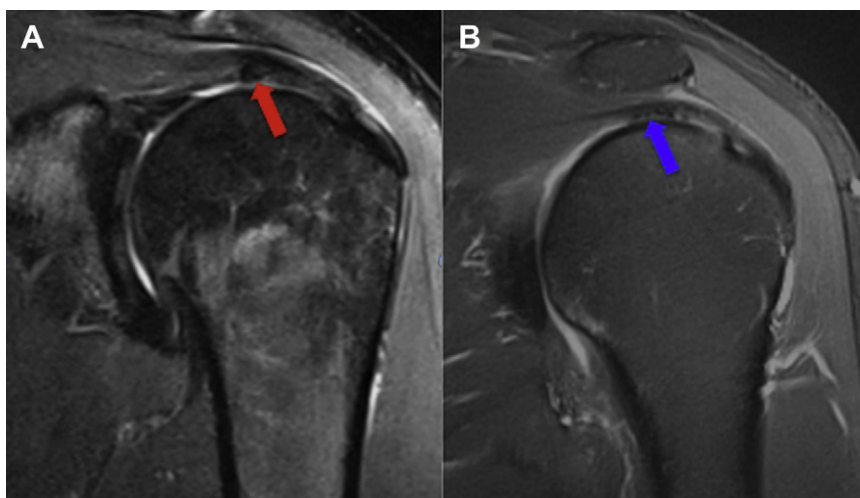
Variations in width and thickness of rotator cable. Coronal oblique fat-suppressed proton-density (A) and T2-weighted (B) images in 2 different patients demonstrate a narrow thick cable (*red arrow* in A) and thin, broad rotator cable (*blue arrow* in B).
